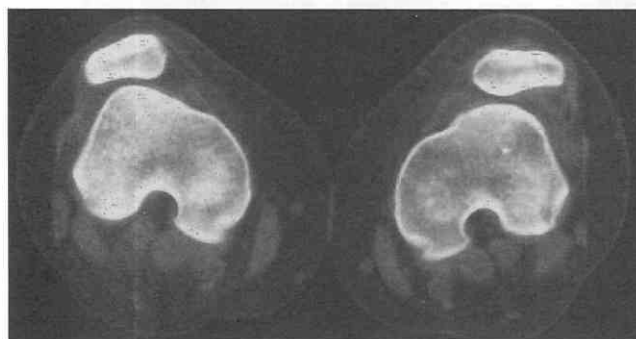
Patellofemoral instability. Axial CT scan shows bilateral patellar femoral subluxation. The femoral trochlea grooves are shallow. A joint effusion is noted on the left.
